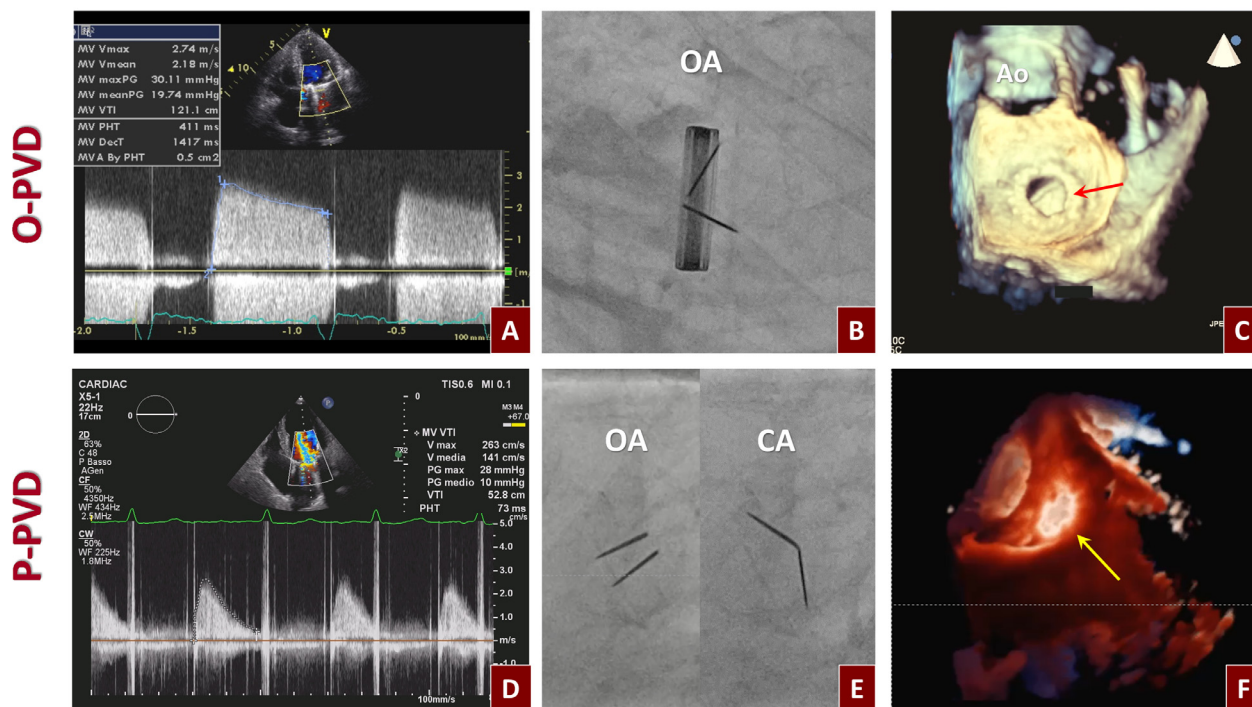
Examples of obstructive and paraprosthetic mitral valve dysfunction. Top. O-PVD: (A) high transprosthetic gradients and prolonged pressure half time detected by continuous Doppler TTE, (B) leaflet restriction at fluoroscopy and (C) at 3D TEE (red arrow). Bottom. P-PVD: (D) increased mitral peak E velocity and high mean transprosthetic gradient with normal pressure half time detected by Doppler TTE, (E) normal leaflet motion at fluoroscopy, and (F) paraprosthetic defect (yellow arrow) at 3D TEE (color version of figure is available online).
